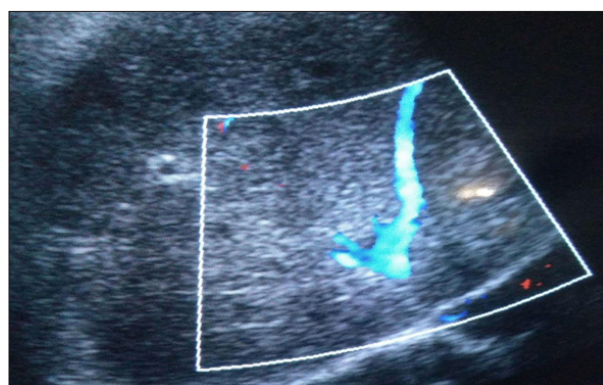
USG SP Axis Doppler showing Prominent Left Hepatic Vein and Non-visualisation of Right and Middle Hepatic Vein
